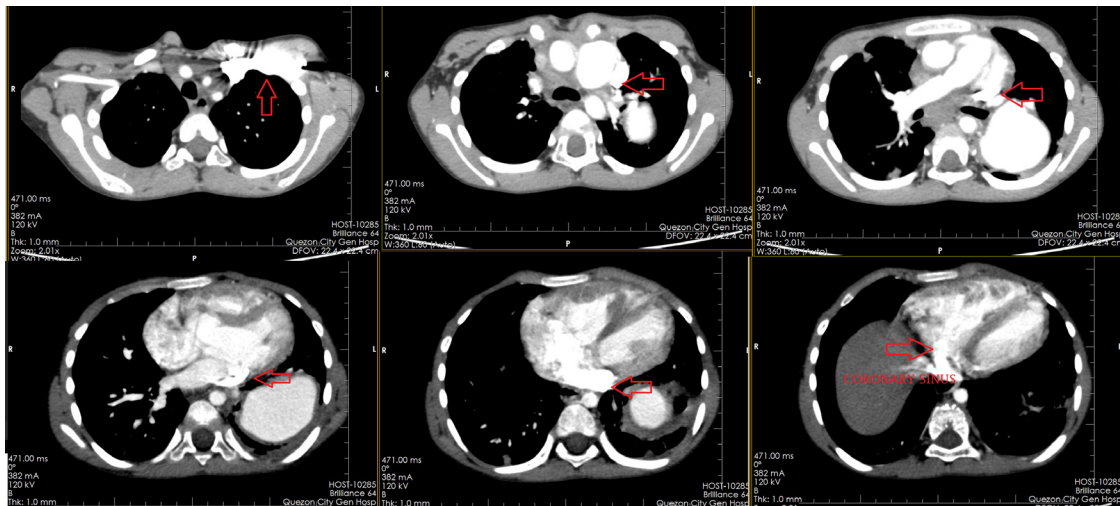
Chest CTA showing the course of the PLSVC from the level of the left common carotid artery up to the coronary sinus.
